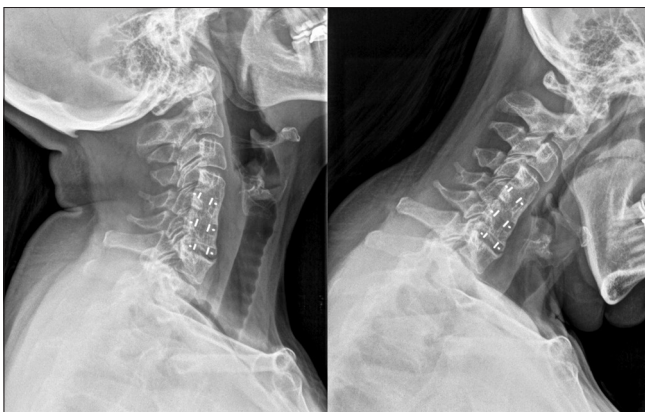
Postsurgery plain radiograph in hyperextension and hyperflexion, used in fusion rate evaluation employing the <1 mm movement between the spinal processes system
